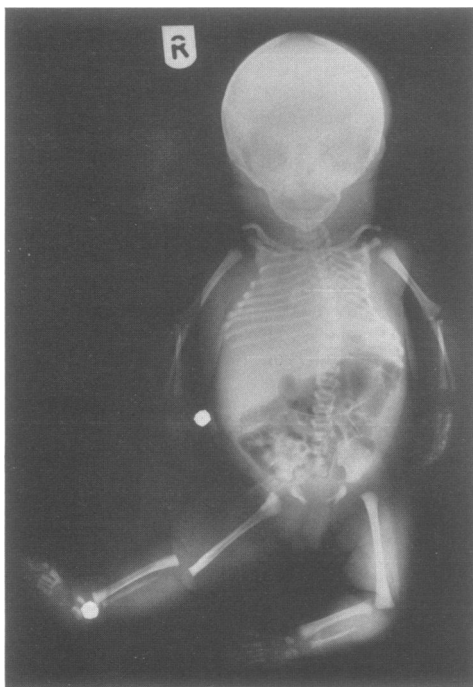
Postmortem radiograph showing hypoplastic thoracic vertebrae and hypoplastic fibulae.
